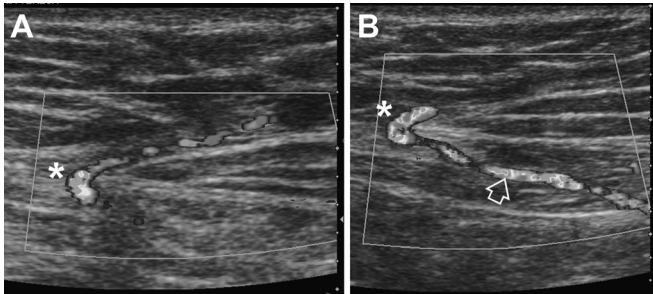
Color Duplex ultrasound of the abdominal wall vasculature, demonstrating a perforator of the deep inferior epigastric artery pedicle, with both the superficial and deep course able to be mapped relative to the point of perforation of the anterior rectus sheath (asterisk in figures A and B). A: The subcutaneous course of a perforator is demonstrated, superficial to the anterior rectus sheath (asterisk). B: The subfascial and intramuscular course of a perforator is demonstrated (arrow), deep to the anterior rectus sheath (asterisk).
